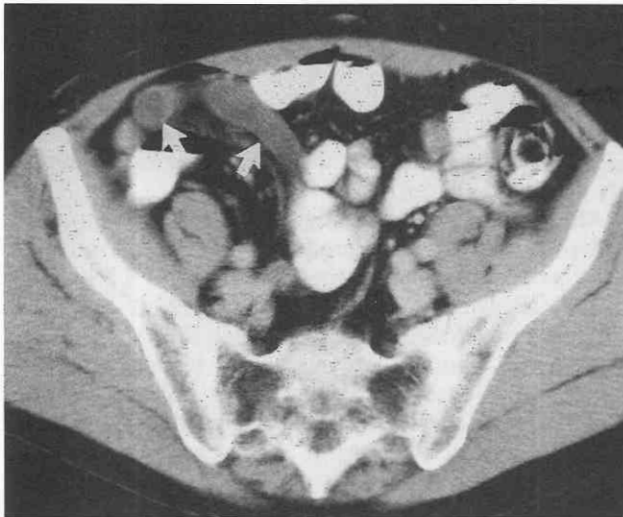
Postcystectomy appearances. CT scan through the pelvis in a patient with an ileal conduit mimicking unopacified small bowel (*arrows*). On adjacent sections, the conduit was able to be followed to the urostomy site (not shown).
